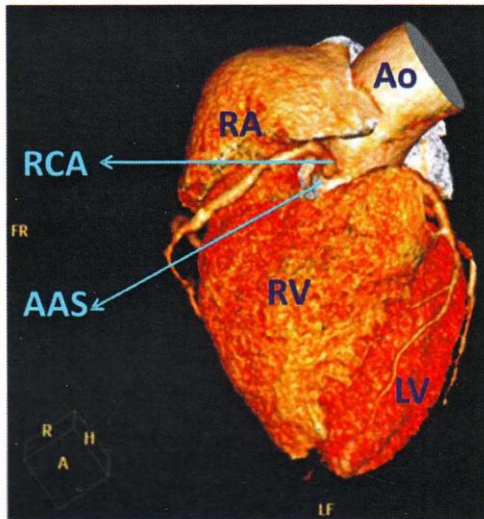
The heart and great vessels: a- anterior view with corresponding 3D reconstructions from multislice CT scanning (b) and c- posteroinferior views showing coronary arteries and their branches RCA- right coronary artery, AM-acute marginal branch of RCA,LCA- left coronary, LAD left anterior descending artery, D- diagonal branch of LAD (Main figures gray's 2008)
